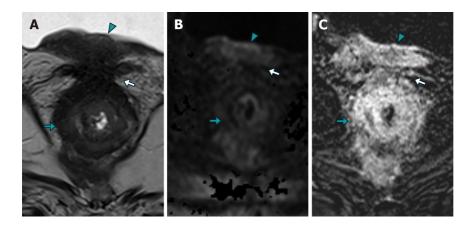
Magnetic resonance imaging findings in case 3. A-C: T2-weighted turbo spin-echo axial imaging (A), diffusion-weighted axial imaging (B), and T1-weighted volumetric interpolated breath-hold examination imaging with contrast-enhanced subtraction (C). The imaging findings revealed a concentric neoplastic involvement of the rectal wall, characterized by areas of intermediate signal intensity on T2-weighted imaging (A), as well as restricted diffusion on diffusion-weighted imaging (correlating with a hypointense region on the apparent diffusion coefficient map, which was not shown; B), and a stratified enhancement pattern on contrastenhanced imaging (green arrow; C). Notably, the imaging also showed neoplastic involvement of the vesico-rectal plane (white arrow) and the bladder floor wall (green arrowhead).
